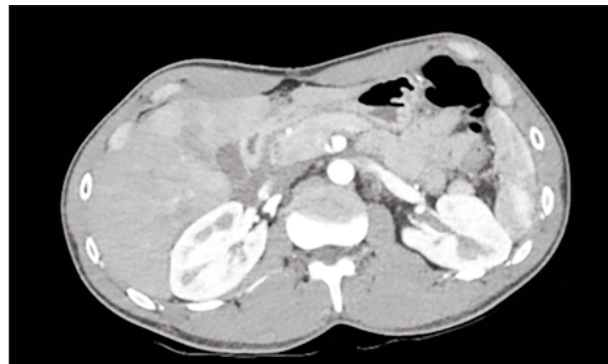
Axial contrast-enhanced CT of the abdomen (arterial phase) demonstrating subtle peripancreatic and perihepatic fluid collection and hepatic parenchymal lacerations.
